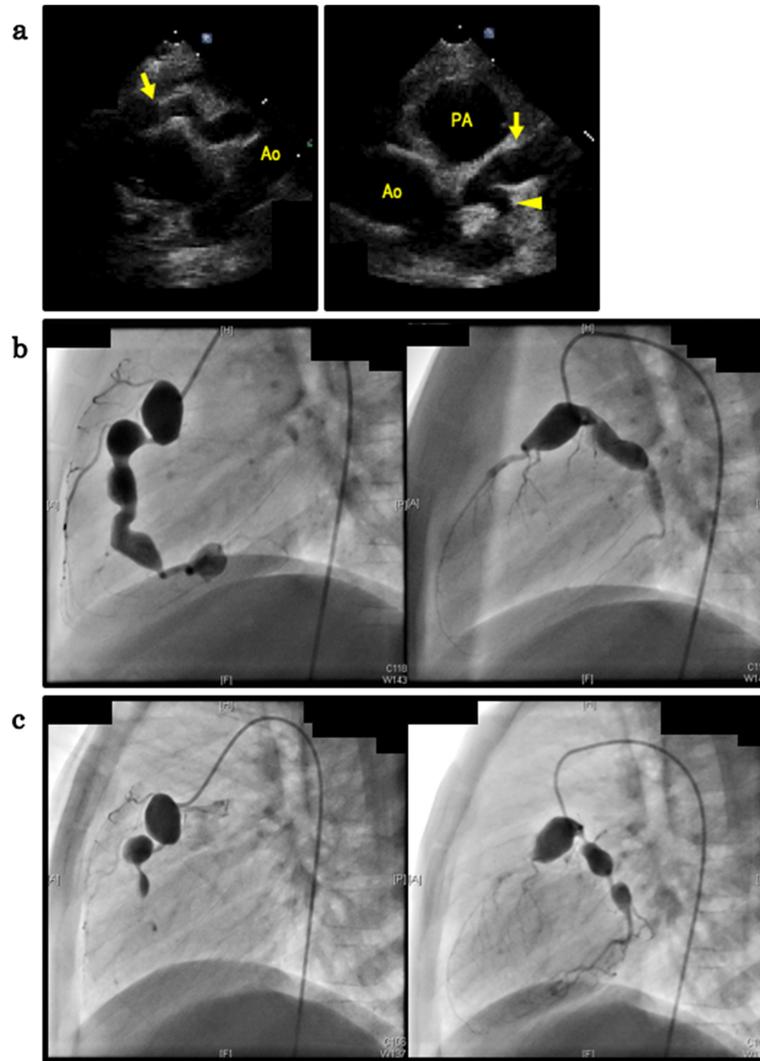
(a) Echocardiography showing normal left ventricular ejection fraction and slight pericardial effusion, with dilatation of all the coronary arteries, as follows: the right coronary artery (RCA) 9.1 mm (Z score 12; the arrow in left panel), the left anterior descending artery (LAD) 7.7 mm (Z score 8.5; the arrow in right panel), and the left circumflex artery (LCX) 3.1 mm (Z score 3.3; the arrowhead in right panel). Ao, Aorta; PA, Pulmonary artery. (b) Coronary angiography performed three months after presentation showing moniliform GA at the RCA and LAD and remarkable dilatation of the LCX (11 mm, 9.9 mm, and 7.7 mm in diameter, respectively). (c) Coronary angiography performed two years after presentation showing the complete occlusion of the RCA with formation of slight collateral circulation
